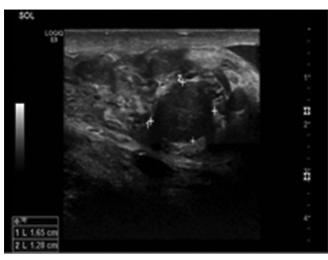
Scrotum Doppler (testis mass)
